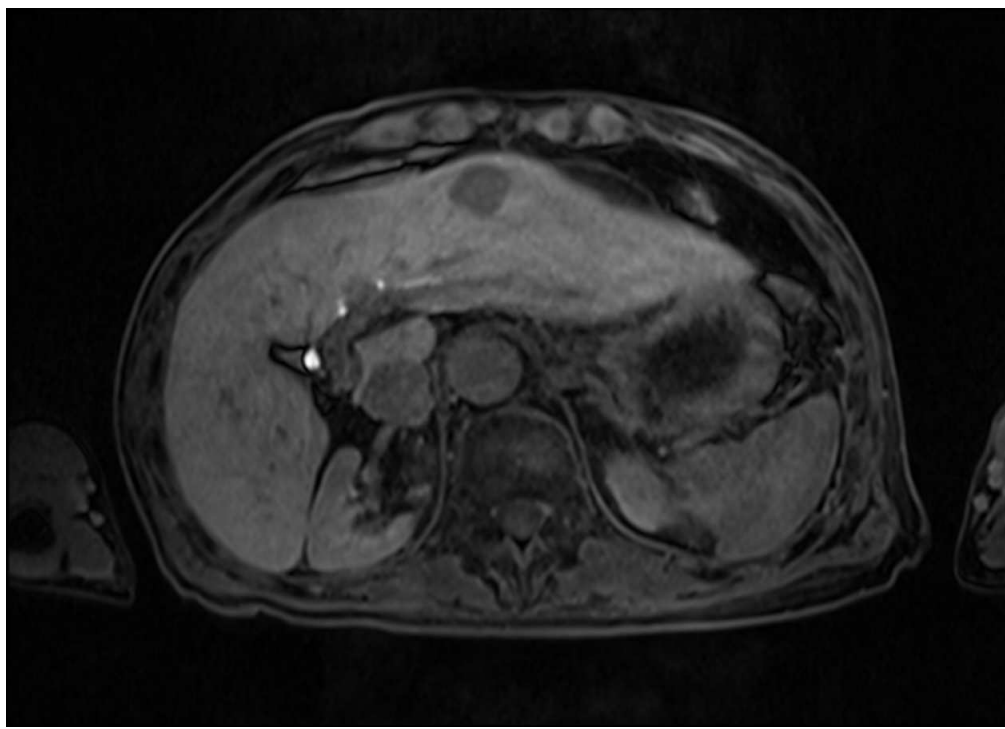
Case #4: A case with heparocellular carcinoma: The contrast between the liver and spleen is low on gadxetate disodium-enhanced MR image. The background liver was proved to be cirrhosis by surgical resection. HUI is low (0.203) representing low ICG-PDR (0.082).
